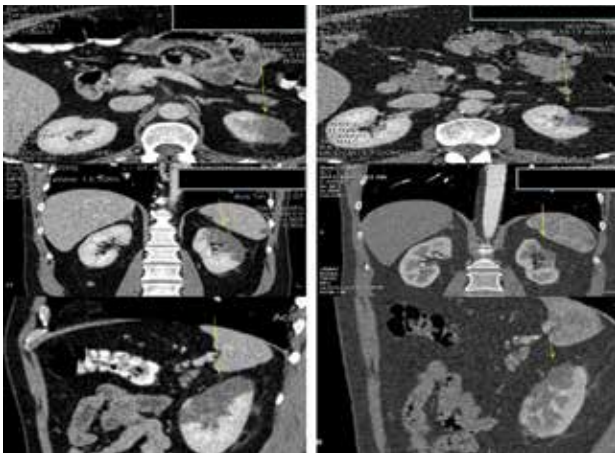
4-months CT follow-up: Axial, coronal and sagittal MPR reconstruction of CT imaging. Comparative images demonstrate the evolution of cortical defect (right column - yellow arrows) in place of renal infarct
